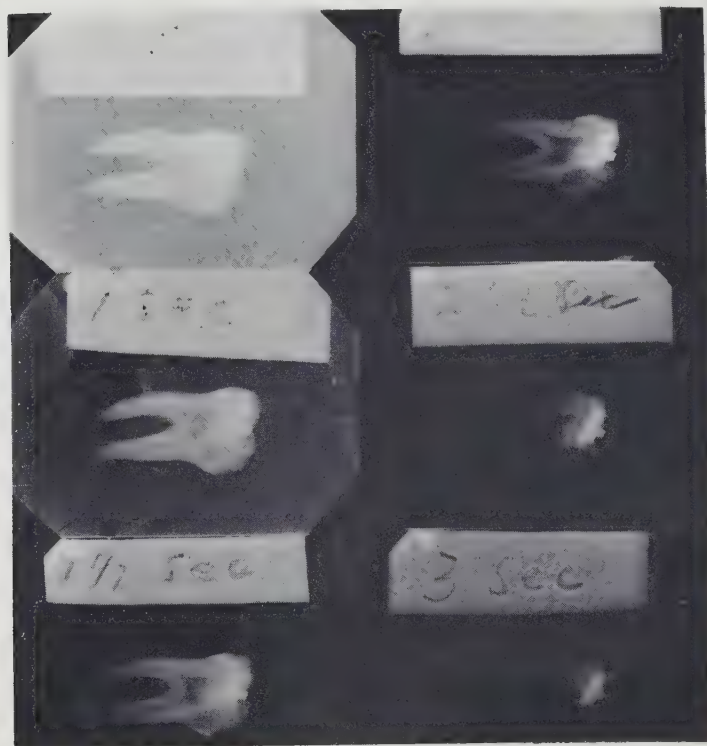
Resultant radiographs of the tooth embedded in plastic which have been given exposures of 1, 1½, 2 and 2½ seconds. Thus the overexposed film (2 seconds) when over-developed is too dark, but the correctly exposed film (1½ seconds) when over-developed is still satisfactory.
